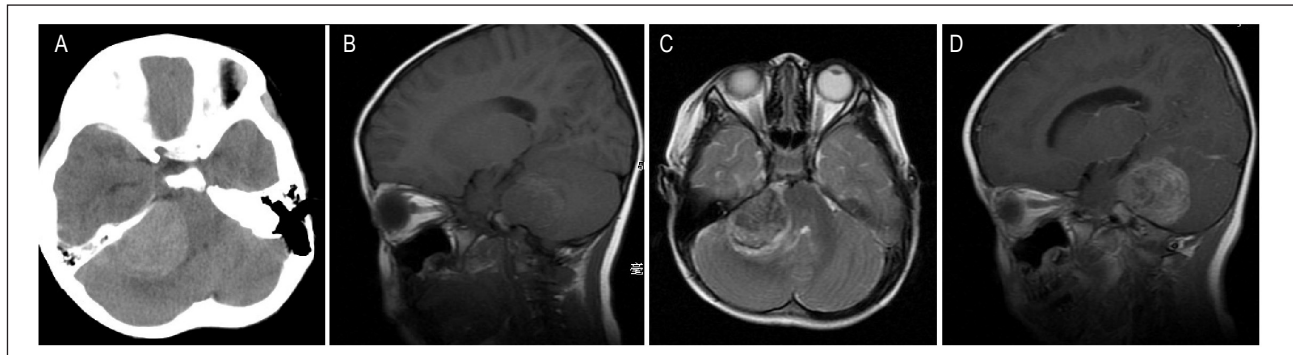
Computed tomography (CT) and magnetic resonance imaging (MRI) of malignant meningioma in the cerebellopontine angle in a 2-year-old girl. A, CT scan of the brain reveals an inordinate globate and defined, slightly high-density lesion in the right cerebellopontine angle. B, T1-weighted MRI shows slightly short signals in the lesion. C, T2-weighted MRI shows long signals in the lesion. D, contrast-enhanced MRI reveals conspicuous heterogeneous enhancement, with patchy un-enrichment. The dural tail sign was visible and measured approximately 38.7 mm × 31.2 mm × 34.7 mm.
